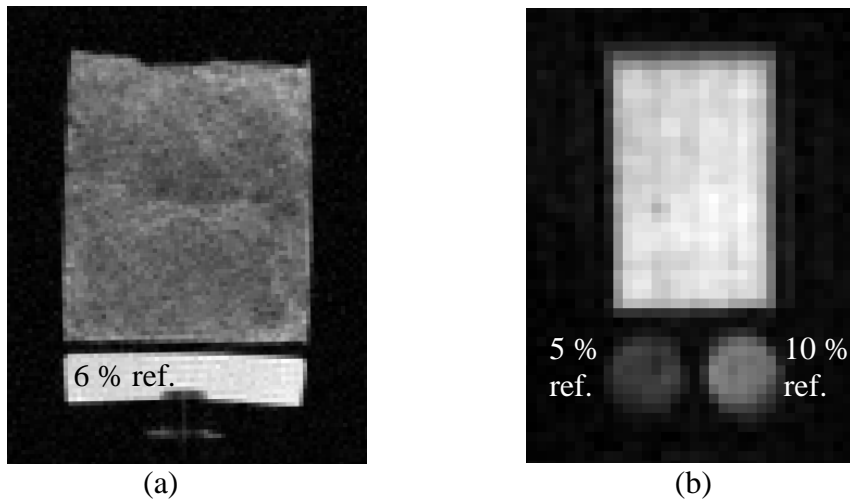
(a) Spin-echo MRI and (b) SPRITE MRI image of the same sample.
